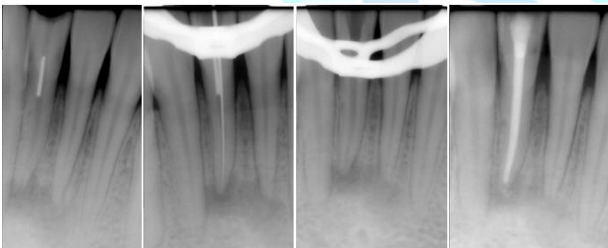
An intraoral periapical radiograph revealed a radio-opaque object in the cervical third of the canal.
